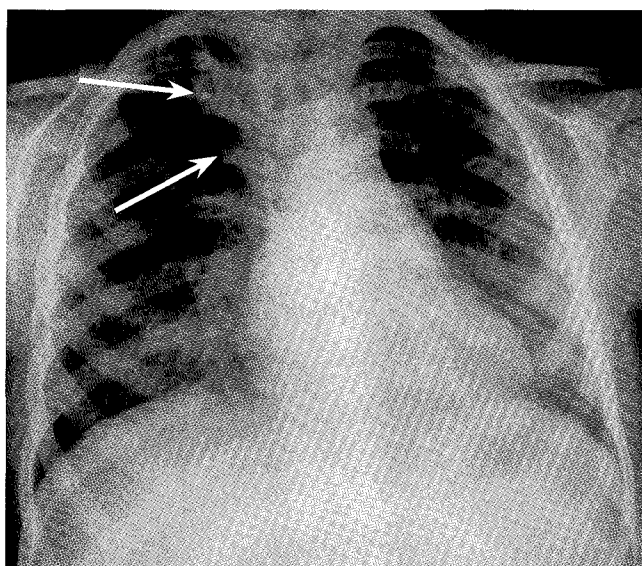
Chest radiograph at 25 days. The right paratracheal density (arrows) has decreased in size but the appearance still suggests a mediastinal mass.
